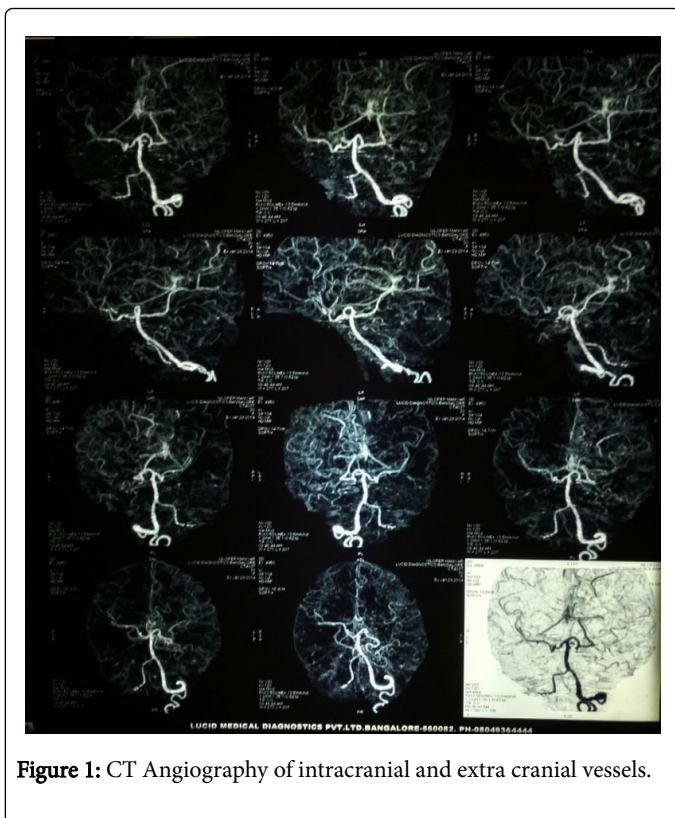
CT Angiography of intracranial and extra cranial vessels.
